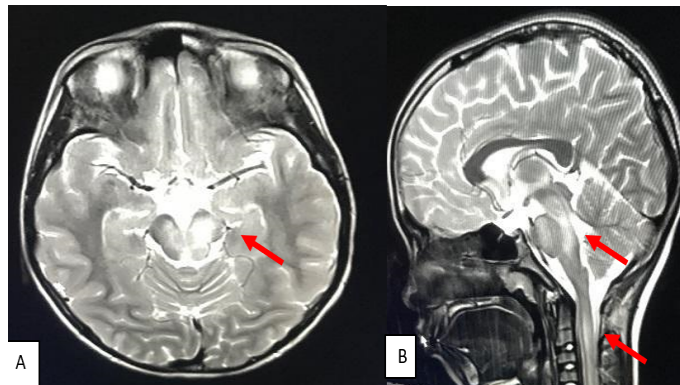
(A-B) MRI showing ill-defined lesions involving posterior part of pons, cerebellar peduncle and midbrain
